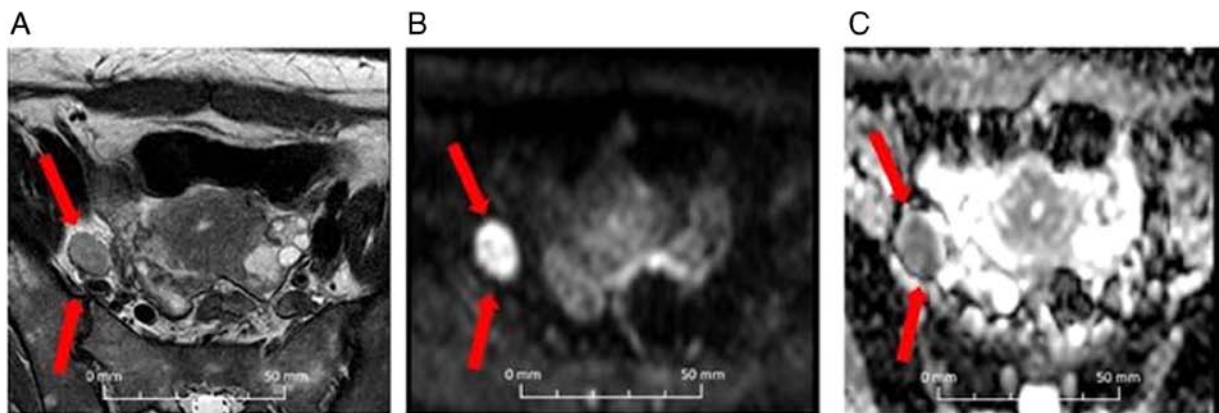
Representative images of a 39-year-old patient with squamous cell carcinoma, at FIGO stage IVA and grade III of differentiation. No lymph nodes metastases were found. MRI images with (A) T2-weighted imaging, (B) diffusion weighted imaging and (C) the apparent diffusion coefficient map are shown. The short-axis diameter measured 14 mm. Red arrows the location of the right pelvic LN with the short axis >10 mm, areas with greater restriction than one would expect for this tissue, a rounded morphology, homogenous appearance with regular limits.
